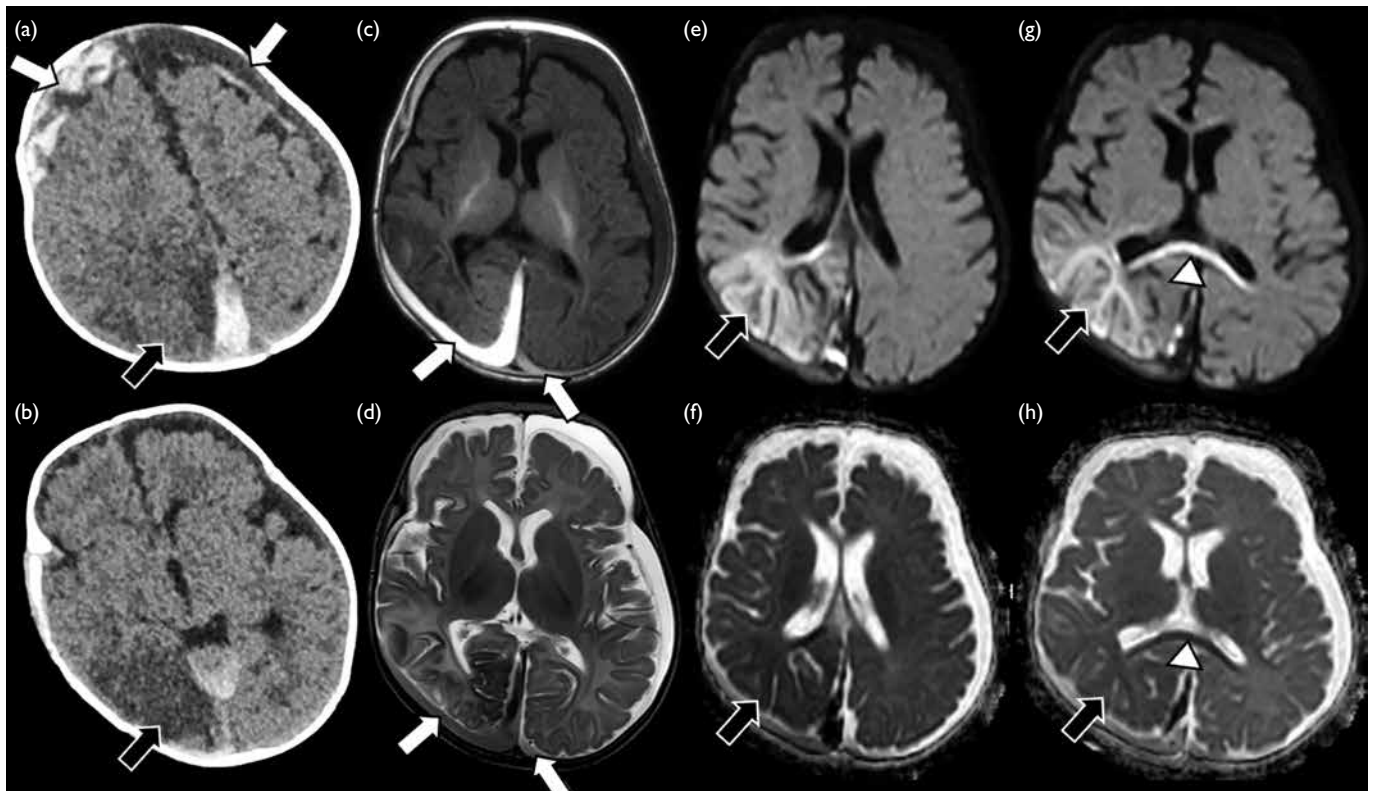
Representative case of shaken baby syndrome. (a, b) Computed tomography of the brain shows mixed-density subdural haematoma along bilateral cerebral convexities, extending into the interhemispheric space (white arrows in [a]). A large hypodense area with loss of grey-white differentiation in the right parieto-occipital region (black arrows) suggests cerebral oedema or hypoxic-ischaemic injury. (c-h) Magnetic resonance imaging of the brain confirms subdural collections of varying intensities over bilateral cerebral convexities and the interhemispheric space (white arrows in [c] and [d]), as well as a large area of restricted diffusion in the right parieto-occipital lobe (black arrows in [e] to [h]), consistent with hypoxic-ischaemic injury. Restricted diffusion in the splenium of the corpus callosum (white arrowheads in [g] and [h]) indicates diffuse axonal injury. (c) T1-weighted imaging. (d) T2-weighted imaging. (e, g) Diffusion-weighted imaging. (f, h) Apparent diffusion coefficient mapping
